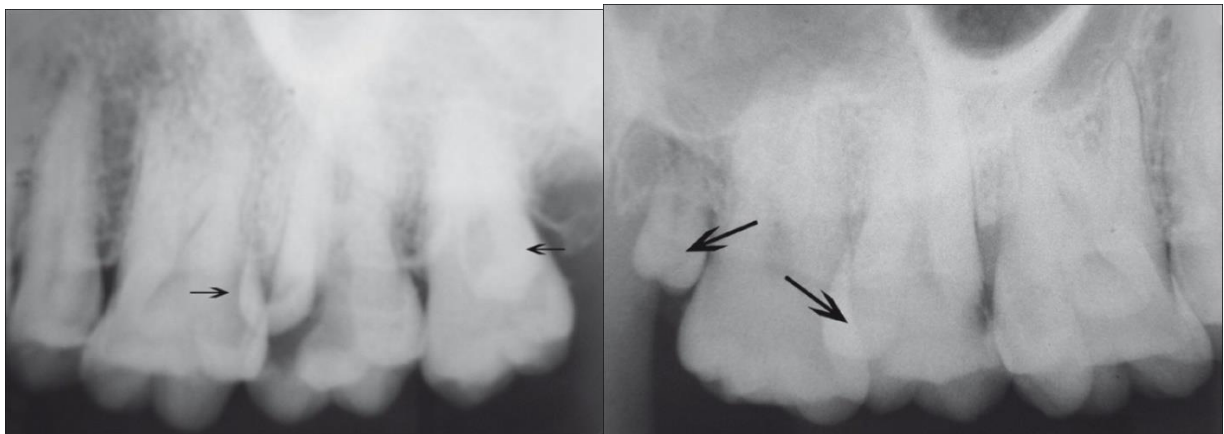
peri-apical radiograph showing carious maxillary right second molar & left second molar
